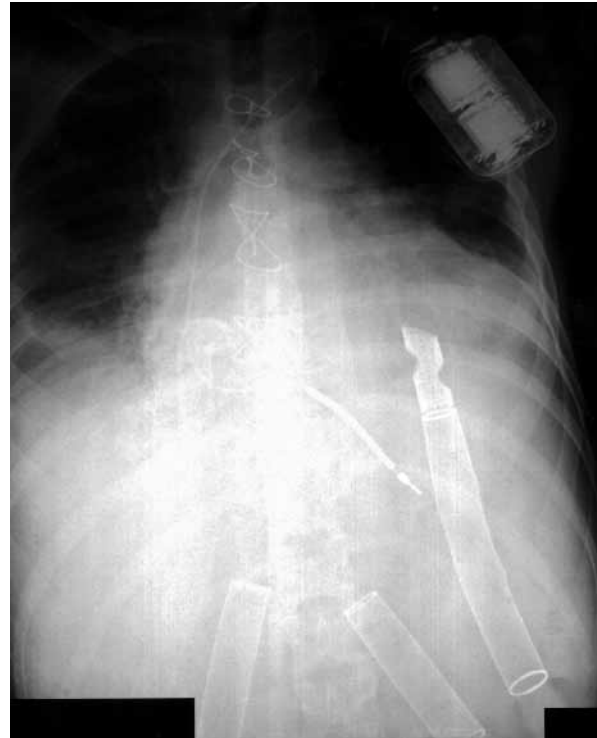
Transthoracic x-ray film showing enlarged heart with biventricular Thoratec inflow and outflow conduits and automated cardiac defibrillator.
